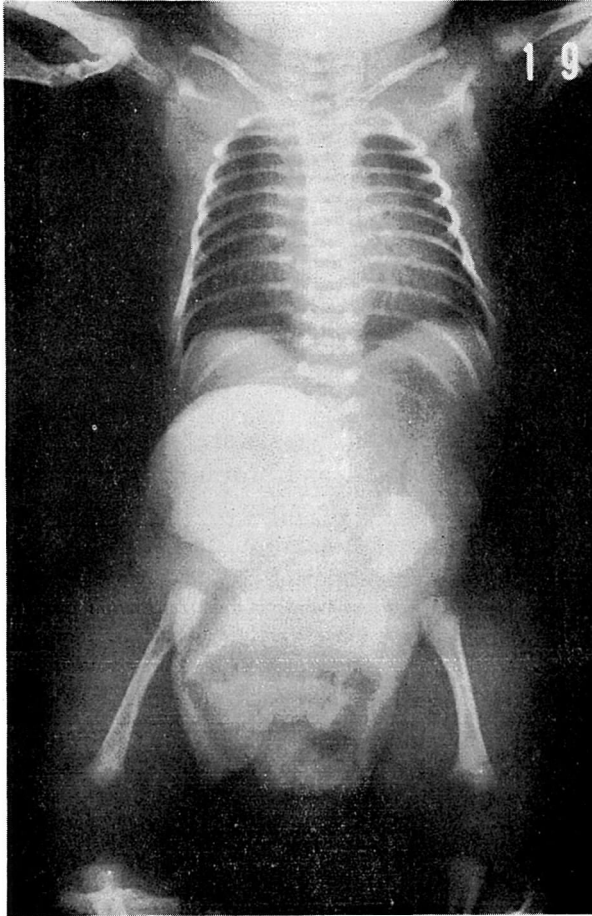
Roentgenogram of the abdomen shows translocation of the intestinal loop into the omphalocele. Note the wide separation of the pubic arch.
